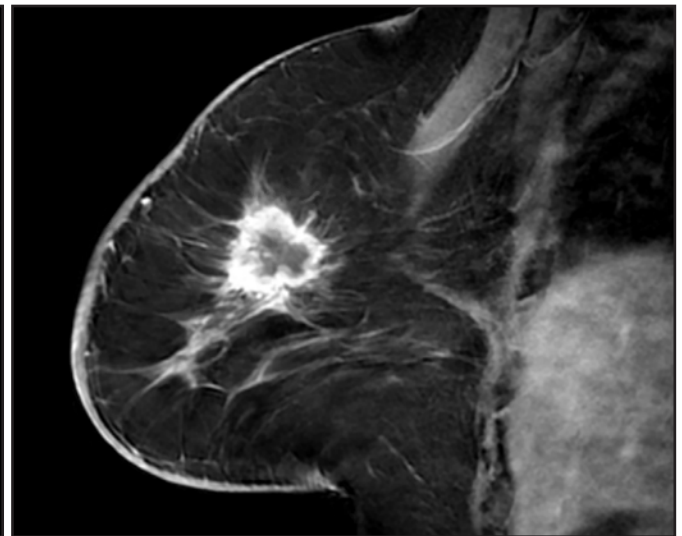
Sagittal T1-weighted, contrast-enhanced fat-subtraction MRI of the right breast demonstrates an irregular fluid collection with thick rim enhancement immediately adjacent to the finding on ultrasound. This was not seen on ultrasound. Biopsy of her lumpectomy bed ultimately showed recurrent IDC.
